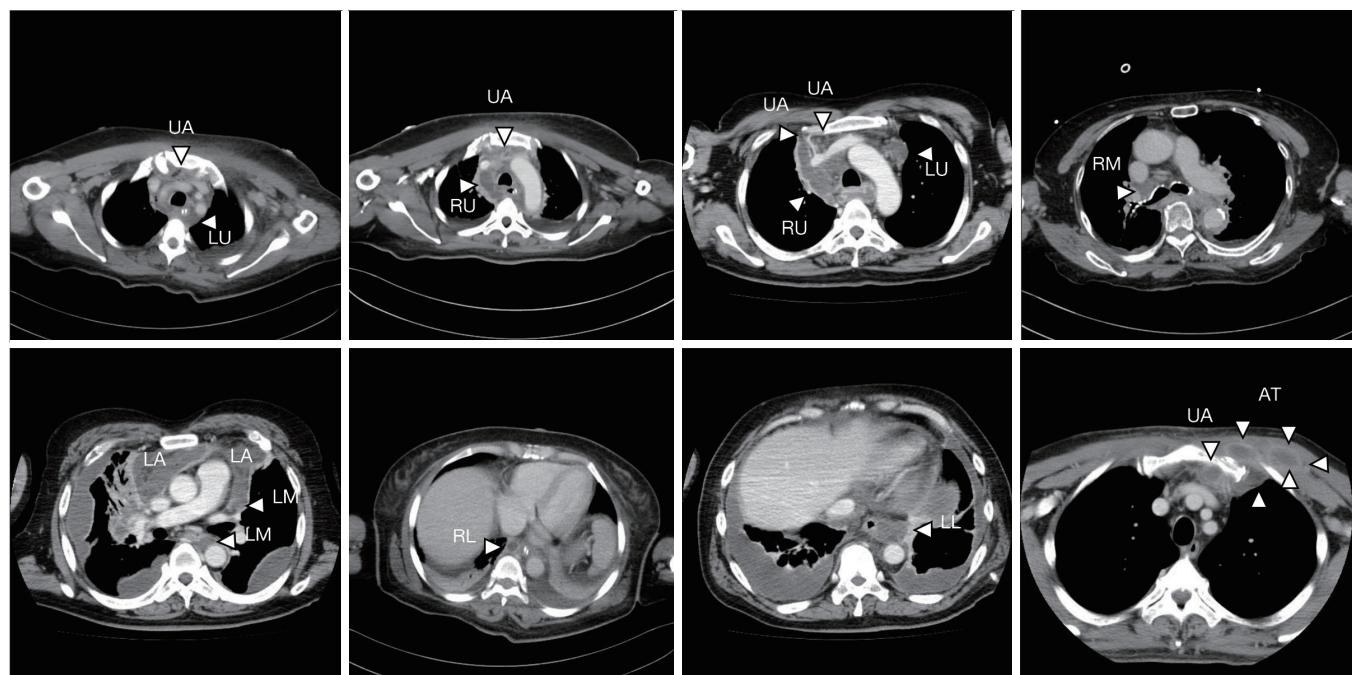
Chest CT findings for each category of thoracic abscess distribution. Upper portion of the anterior compartment (UA), lower portion of the anterior compartment (LA): right upper portion of the middle compartment (RU), left upper portion of the middle compartment (LU), right middle portion of the middle compartment (RM), right lower portion of the middle compartment (RL), left upper portion of the middle compartment (LM), right lower portion of the middle compartment (LL) and anterior thoracic wall (AT).
